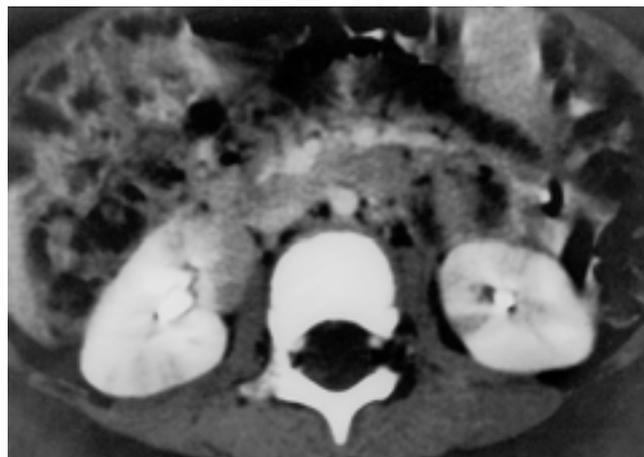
CT pattern IIB in a 3 year-old-boy who had fever for 3 days with 39.5 , and 11 days of admission periods. Postcontrast CT shows multiple linear and wedge shaped hypo-enhancing lesions in both kidneys, which resolved completely without cortical scar on 4 month follow-up CT scan (not shown here).
